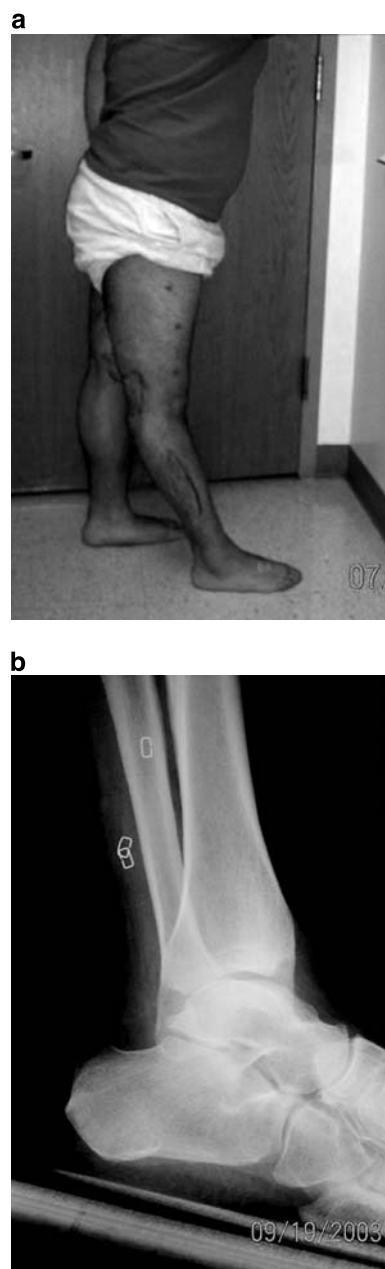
a Side view showing an equinus contracture of the ankle associated with a foot forward position and hyperextension at the knee. b Lateral radiograph showing the equinus contracture of the ankle
